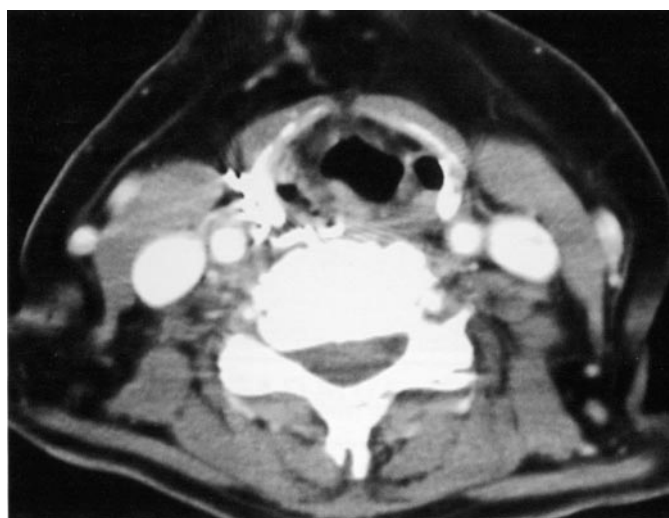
Patient 1. CT scan of the neck 20 d after the episode showing reduction of tracheal compression.
